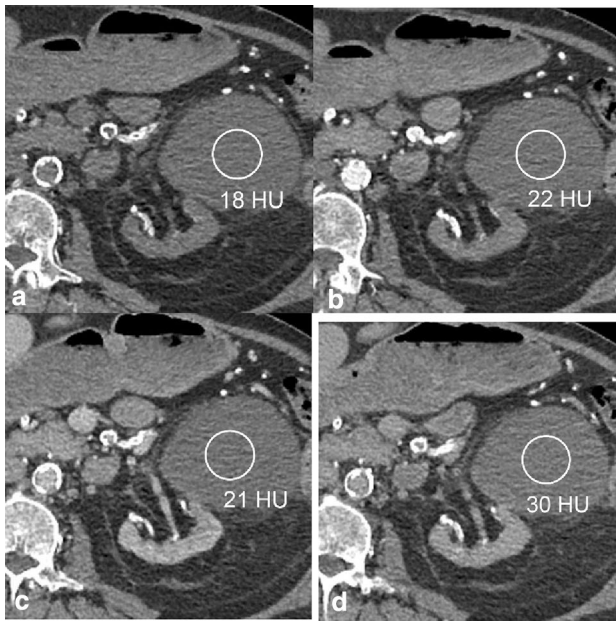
Multiphase renal CT for the patient in Case 2 with noncontrast (a), corticomedullary phase (b), nephrographic phase (c), and delayed phase (d) images. Enhancement was equivocal within the left perirenal lesion
